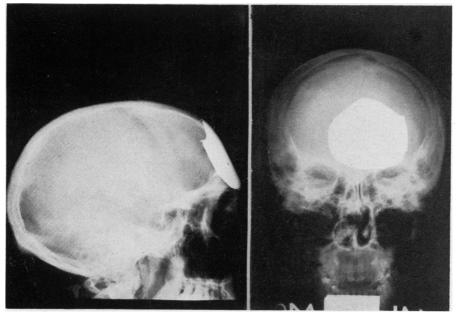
Case 1: Roentgenograms of tantalum plate inlayed in bifrontal defect and early postoperative cosmetic result. The broad scar of the original injury may be removed at a later date.
